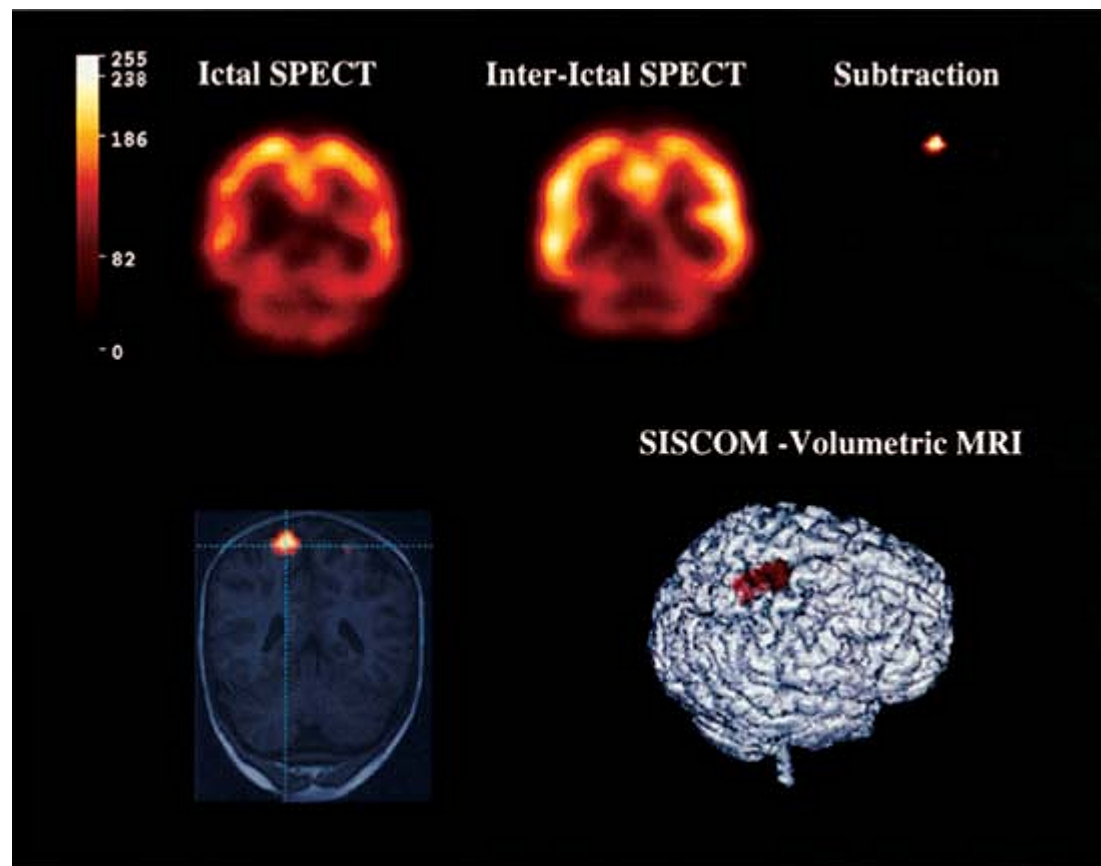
Steps to obtaining subtraction ictal SPECT (single photon emission computed tomography) coregistered to MRI (magnetic resonance imaging) (SISCOM) image. Ictal (*upper left*) and interictal (*upper middle*) SPECT images are obtained. After normalization of their mean intensities and coregistration with each other, subtraction is performed to obtain a “difference” image (*upper right*). The difference image is then coregistered with MRI at specific planes (*lower left*) or on the surface of a three-dimensional MRI (*lower right*). (From So E. Role of neuroimaging in the management of seizure disorders. *Mayo Clin Proc.* 2002;77:1251-1264, with permission.) (See black and white image.)
